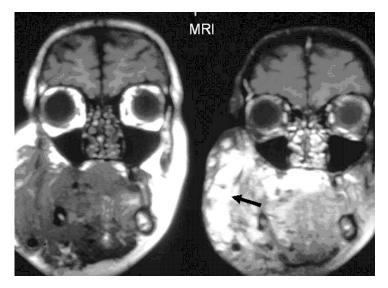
MRI with T1- (left) and contrast enhanced fat suppressed T1-weighted image (right) showing a large subcutaneous mass of the right cheek consisting of partially open venous pouches (arrow).
